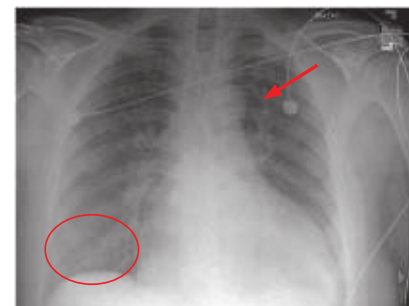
X-ray of the chest (CXR) with evidence of congestive heart failure. Frontal CXR demonstrates marked cardiomegaly, cephalization of vessels (arrow), interstitial edema (circle), and small left-sided pleural effusion, which raise concern for CHF. (Reproduced with permission from Tintinalli JE et al. *Tintinalli’s Emergency Medicine: A Comprehensive Study Guide*. 7th ed. New York, NY: McGraw-Hill; 2011.)
